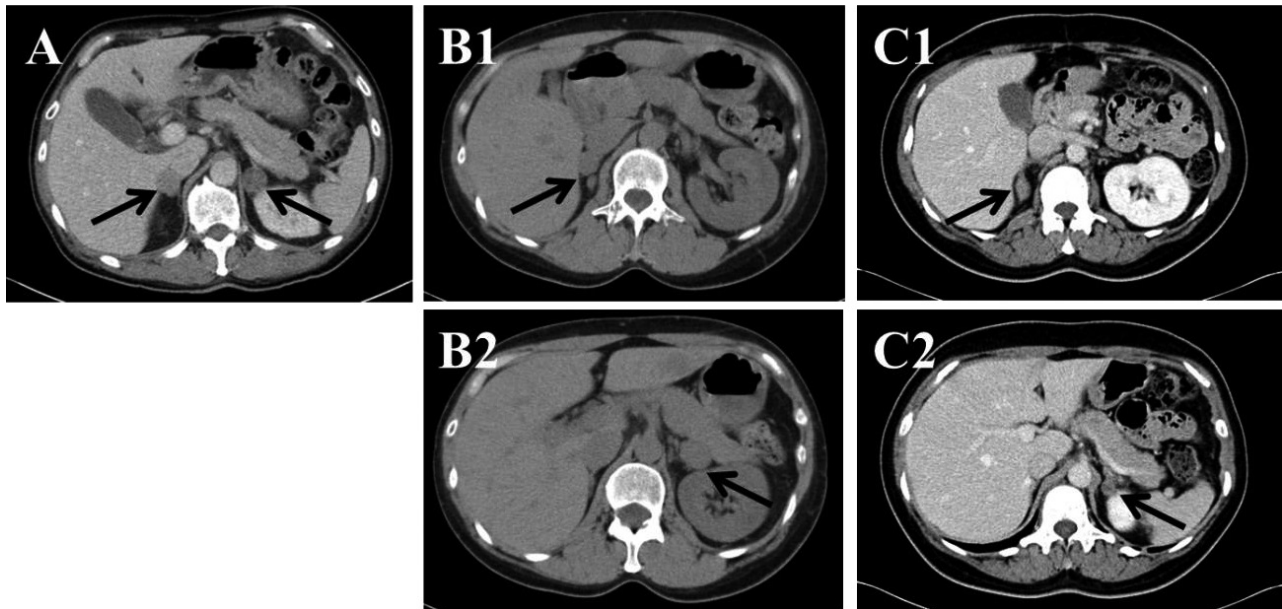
Abdominal computed tomography (CT) scans of the abdomen. Bilateral adrenal tumors (arrows) and atrophied glands were observed. Each tumor was composed of well-circumambulated masses, without apparent irregularity on the surface or inside. (A: case 1, B1 and B2: case 2, C1 and C2: case 3).
